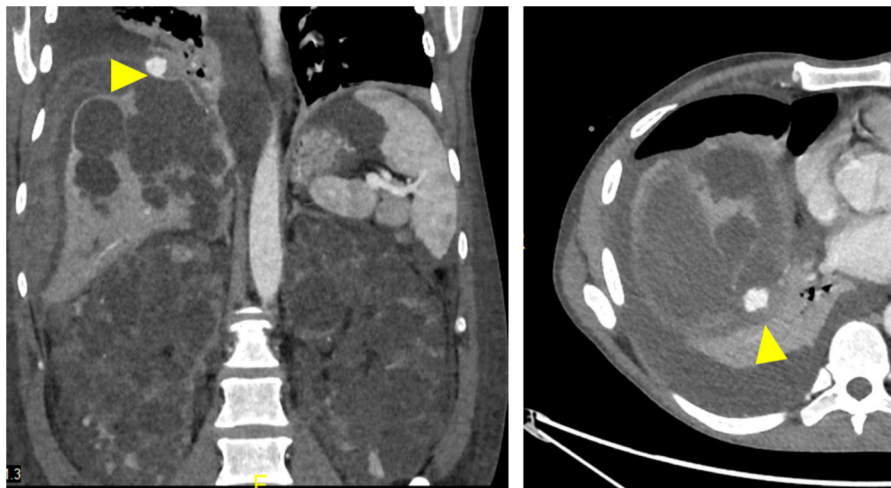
Coronal (left image) and axial (right image) CT angiography showing a large subcapsular pseudoaneurysm (yellow arrowhead) in the right lobe, posterior to the bare area of the liver. Note is made of enlarged polycystic kidneys, with significant hepatic involvement.
